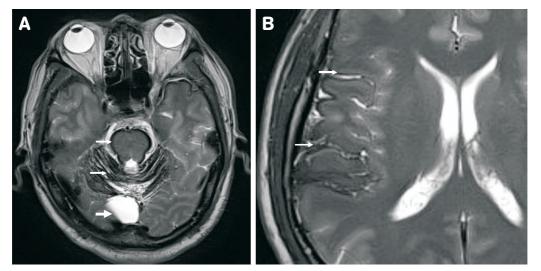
(A): T2-weighted MRI image showing linear hypointensities along the surfaces of the brainstem and cerebellum (thin arrows) as well as cerebellar atrophy. There is a retro-vermian cerebellar arachnoid cyst (thick arrow).
